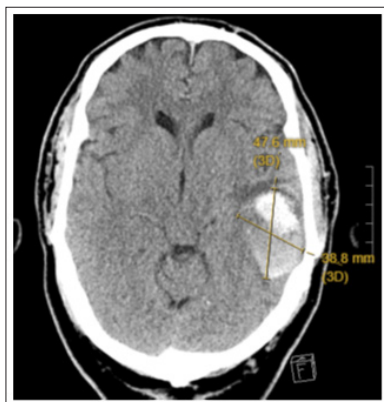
CT Head without Contrast Demonstrating Acute ICH in the left Temporal-Parietal Region
